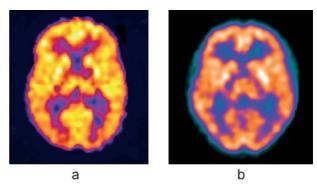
(*a*) FDG-PET scan of normal 45-year-old brain and (*b*) rCBF-SPECT scan of a normal 35-year-old brain.
